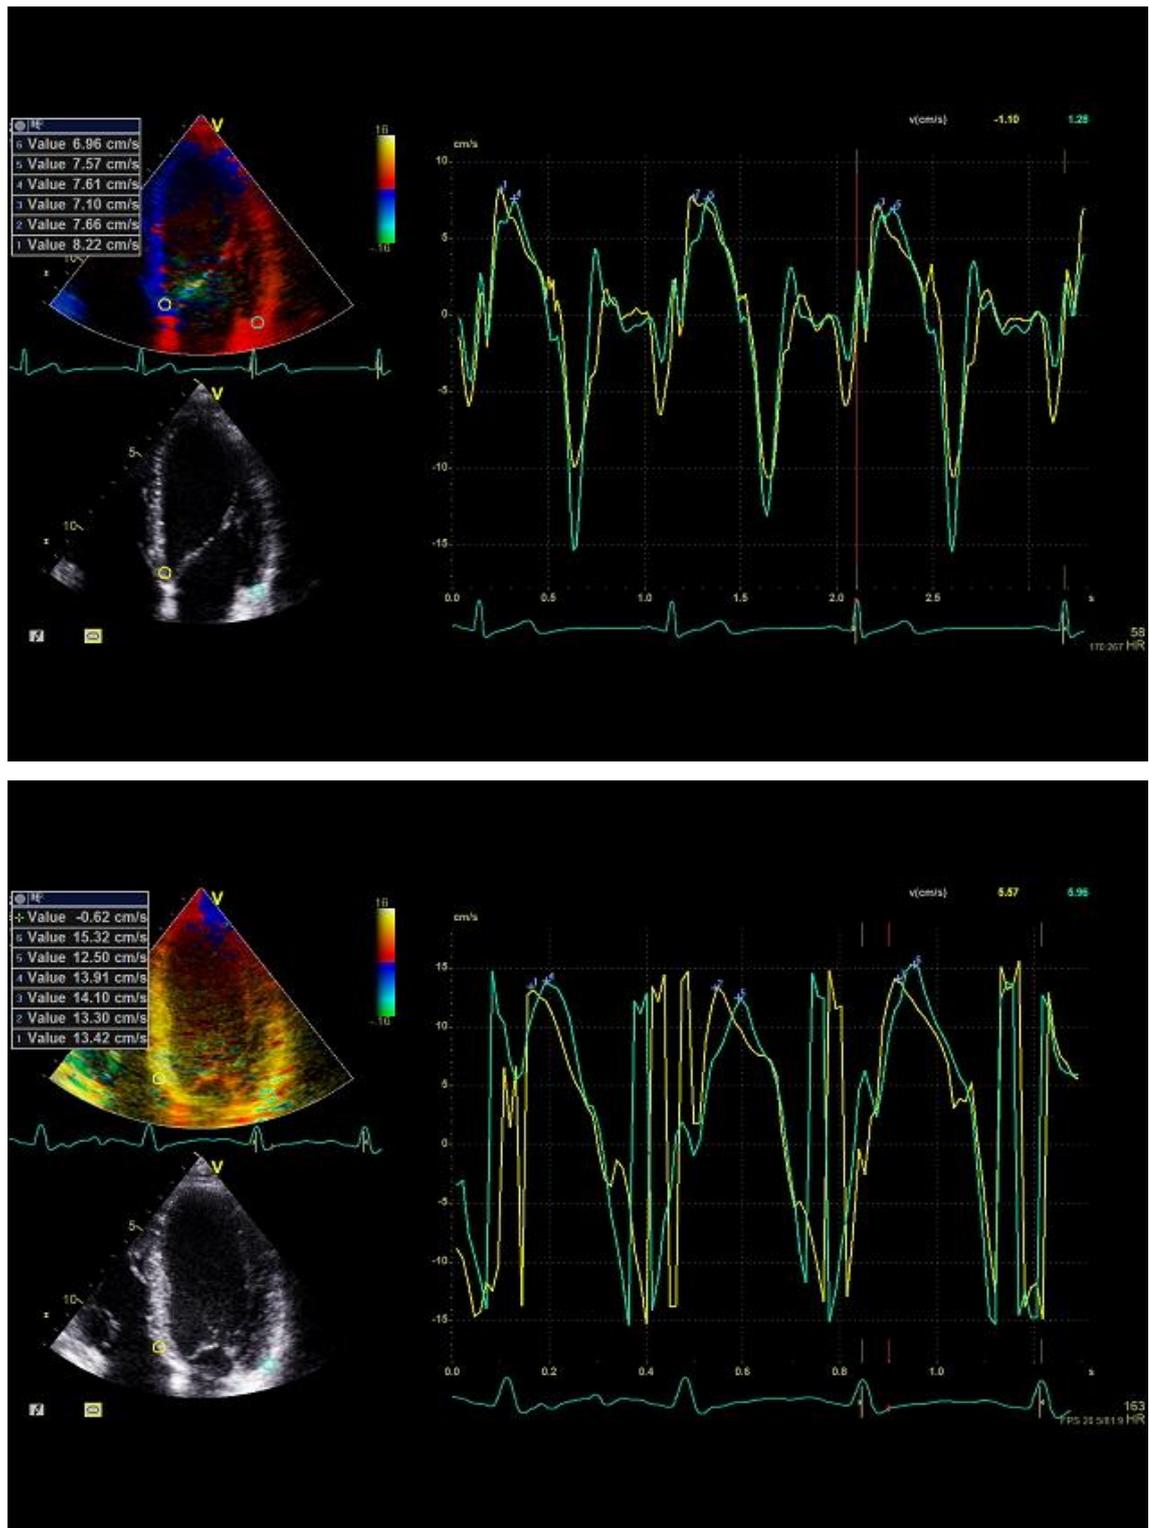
Tissue Colour Doppler at rest (top) and peak exercise (bottom) obtained from the septal and lateral basal segments demonstrating an increase in systolic longitudinal function
